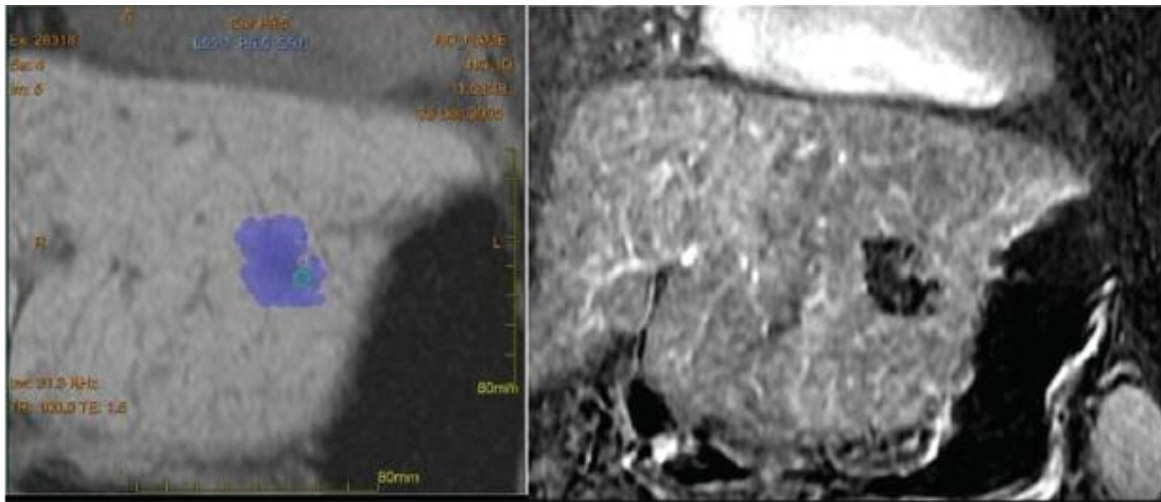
MRgFUS of hepatocellular carcinoma. Left: Post-treatment image in coronal plane showing entire thermal dose. Right: contrast-enhanced MRI showing focal nonperfusion [18].
